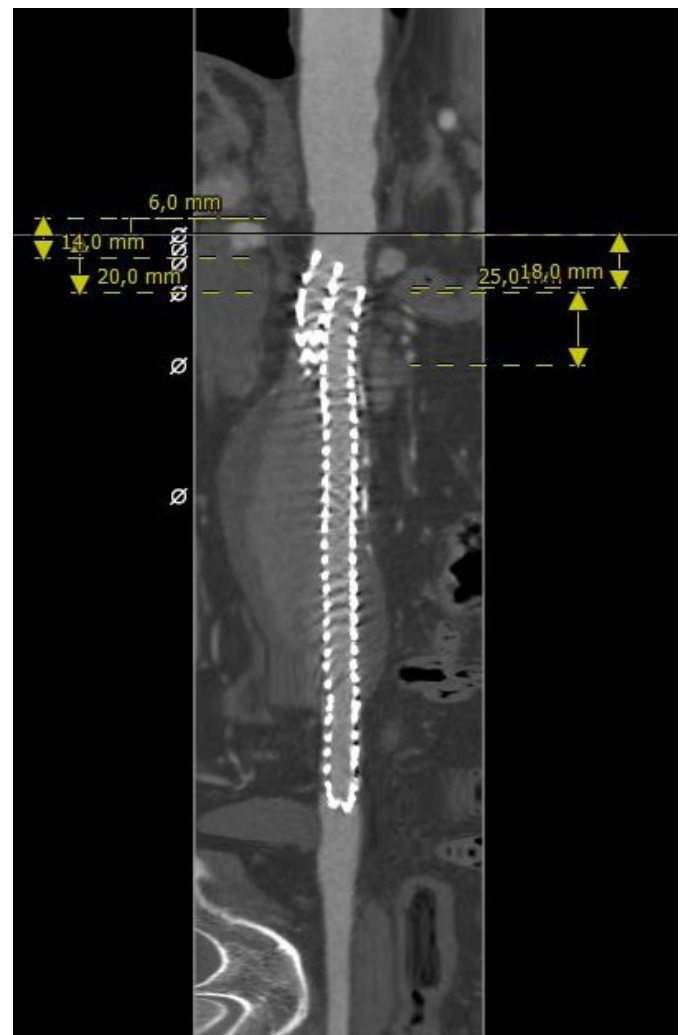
A year later, the CTA recorded an even more pronounced migration and loss of proximal sealing. The indication for surgery was set.
